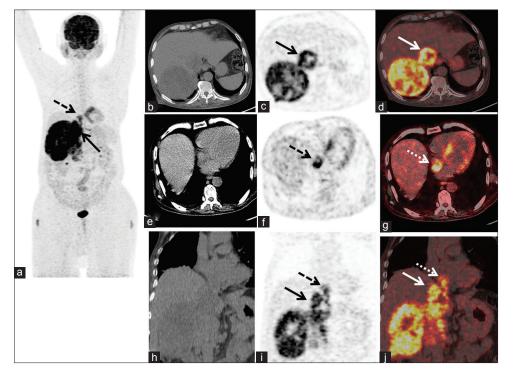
(a) MIP of PET-computed tomography image showing FDG uptake in the right hypochondrium of the abdomen. (b) Axial computed tomography image showing right suprarenal mass and hypodense lesion in inferior vena cava showing increased FDG uptake in PET (c, solid black arrow) and fused PET-computed tomography image (d, solid white arrow). (e) Hypodense lesion in the right atrium showing FDG uptake in the PET (f, dashed black arrow) and fused PET-computed tomography (g, dashed white arrow). (h-j) Coronal images showing FDG avid tumor thrombus extending from the inferior vena cava (solid black and white arrows) to the right atrium (dashed black and white arrows)
